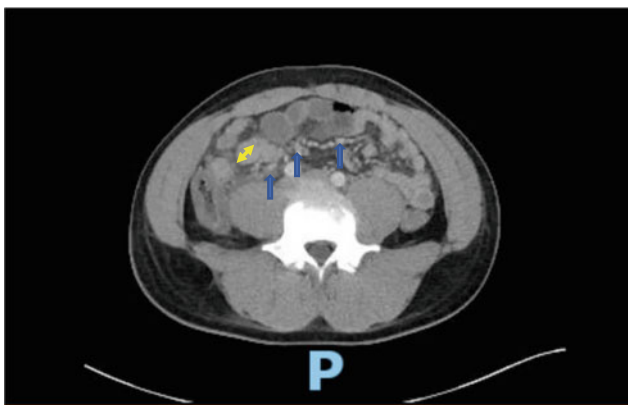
CT angiogram of the chest, abdomen, and pelvis with abdominal slice showing ascending colitis, terminal ileitis and a mass (yellow arrow), mesenteric lymphadenopathy (blue arrows)
